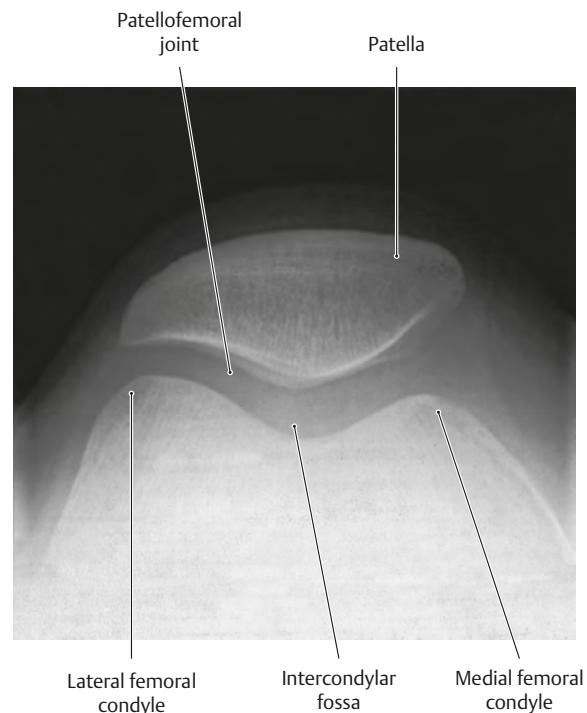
Radiograph of the knee in flexion
